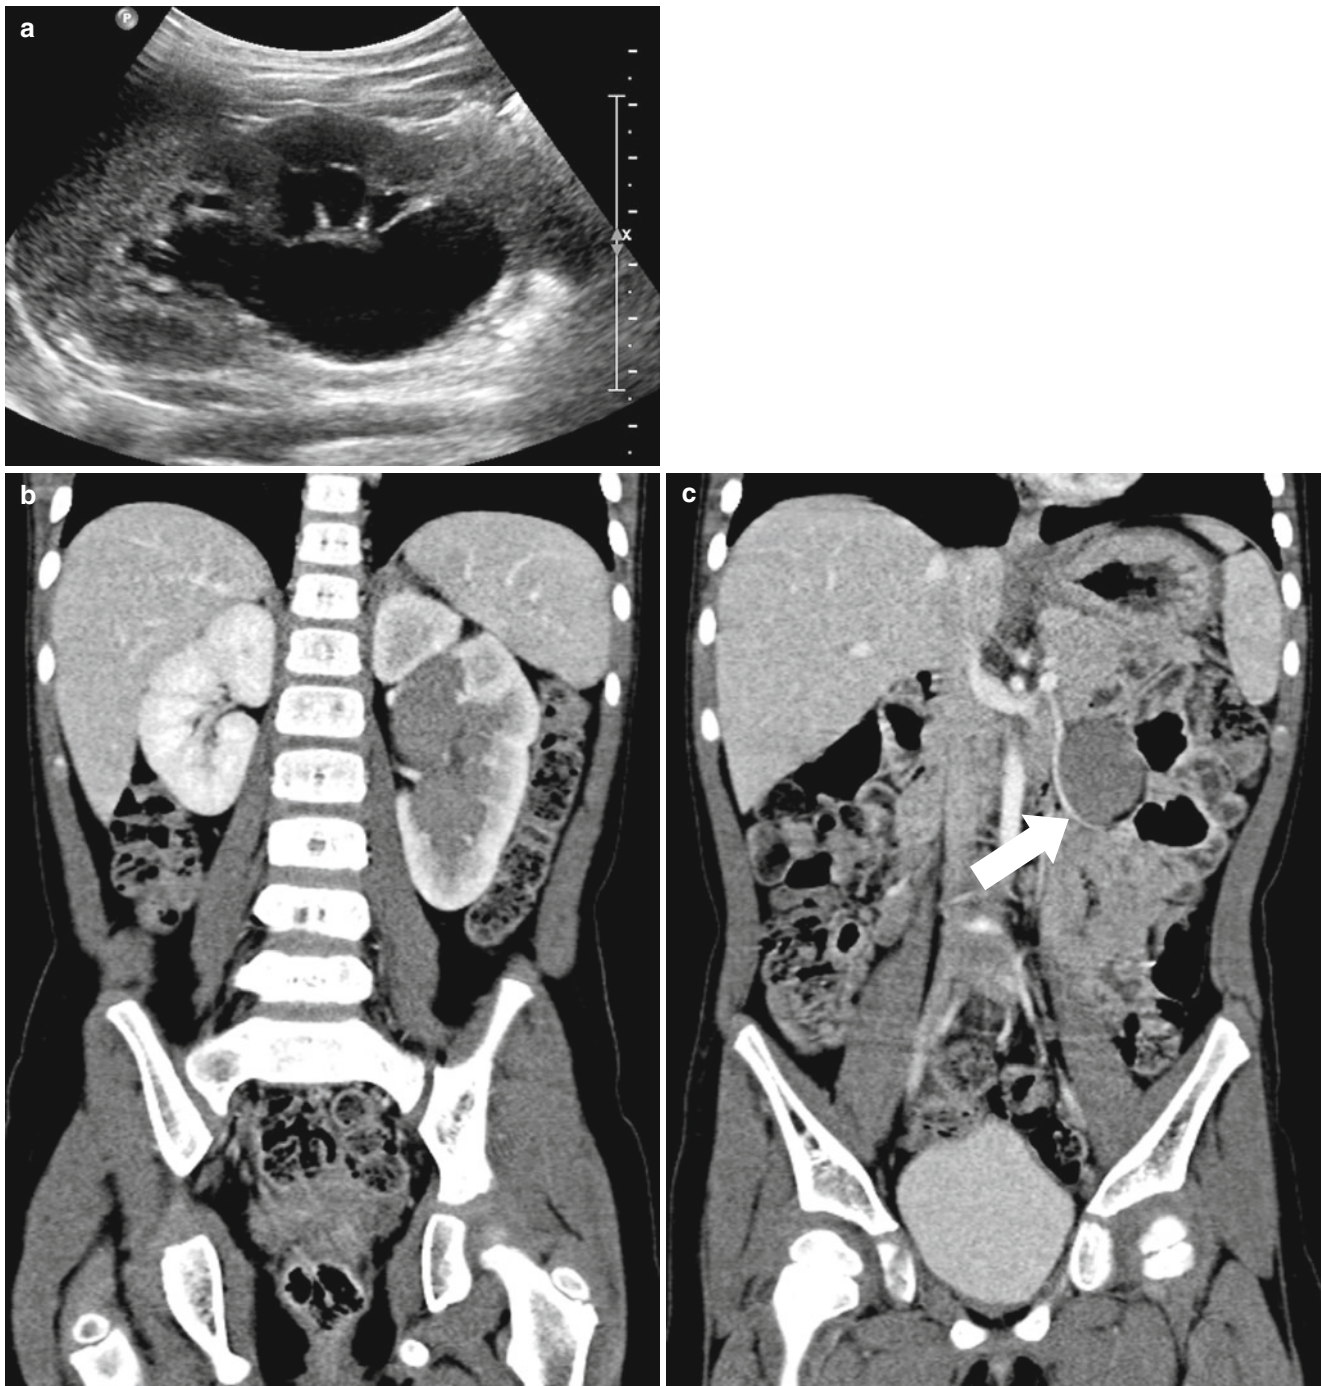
Ureteropelvic junction obstruction due to crossing vessel in a 3-year-old girl. (a) Longitudinal US image of left kidney shows hydronephrosis without ureter dilatation. (b) Contrast-enhanced CT scan with coronal reformat image demonstrates hydronephrosis of left
